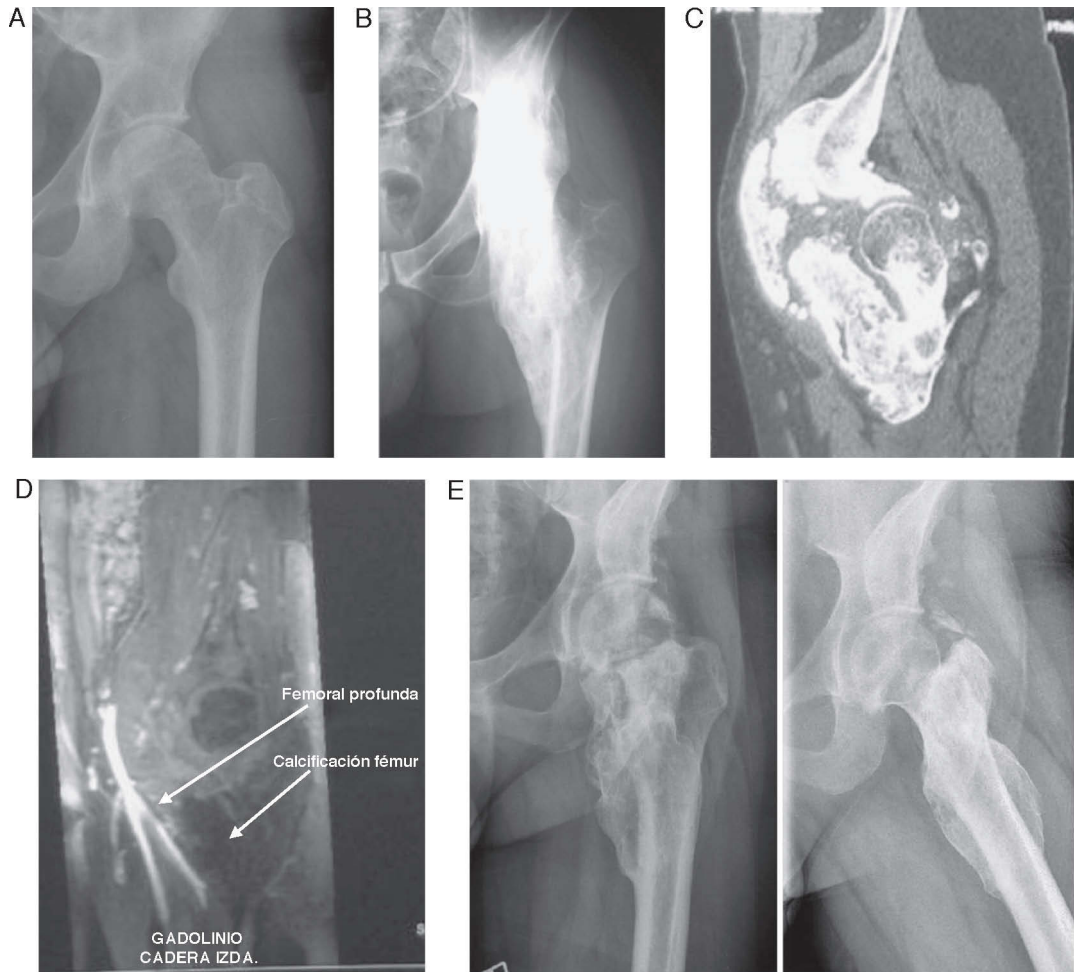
Images for case 1. A) X-ray of left hip 6 months after the trauma, with no visible ossification. B) Anteromedial ossification from iliac wing to proximal femur. C) CT of hip where heterotopic ossification is appreciated in the anteromedial aspect, encompassing the iliopsoas muscle. D) MR Angiography: displacement of the femoral artery and vein due to the ossification and association with the lateral circumflex artery. E) Anteroposterior and axial x-rays at 24 months after the surgery.
